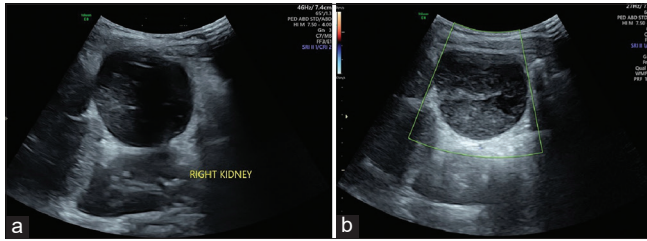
(a) Ultrasound (USG) B mode shows a well-defined hypoechoic lesion with internal low-level septations with possibilities of necrotic node or omental torsion (b) USG color Doppler show no uptake of color flow.
